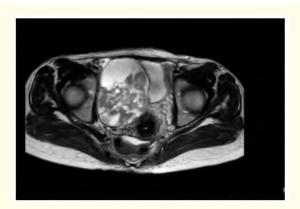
Axial T2-weighted pelvic slice passing through the right ovarian lesion.
